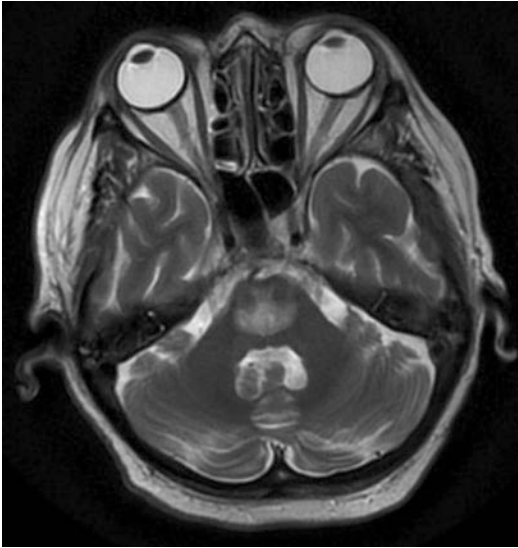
MR imaging, T₂-weighted, demonstrating osmotic demyelination in a 63-year-old woman after rapid correction of hospital-acquired hyponatremia (developed within 48 h)
